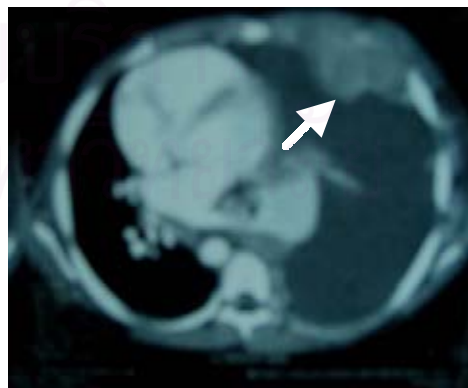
1B. Chest roentgenogram (1A) showed a haziness over left hemithorax with mediastinal shift to the right. Computed tomography of the chest (1B) revealed massive left pleural effusion with multiple masses over left pleura and adjacent anterior chest wall (Arrow).
